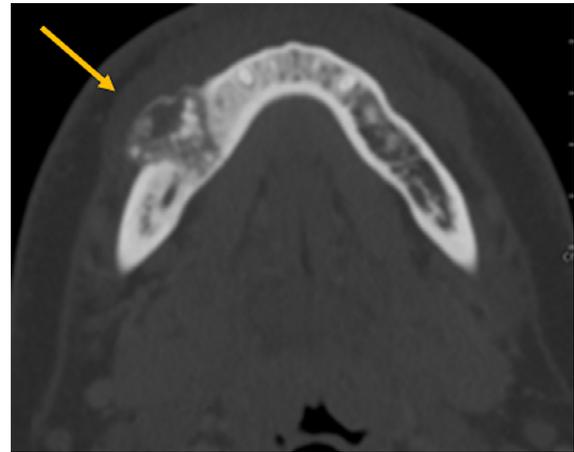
Axial computed tomography (CT) bone window section revealed a mixed sclerotic and lytic destructive lesion in the body of the right hemi-mandible. Surrounding reactive bone sclerosis was also present.
